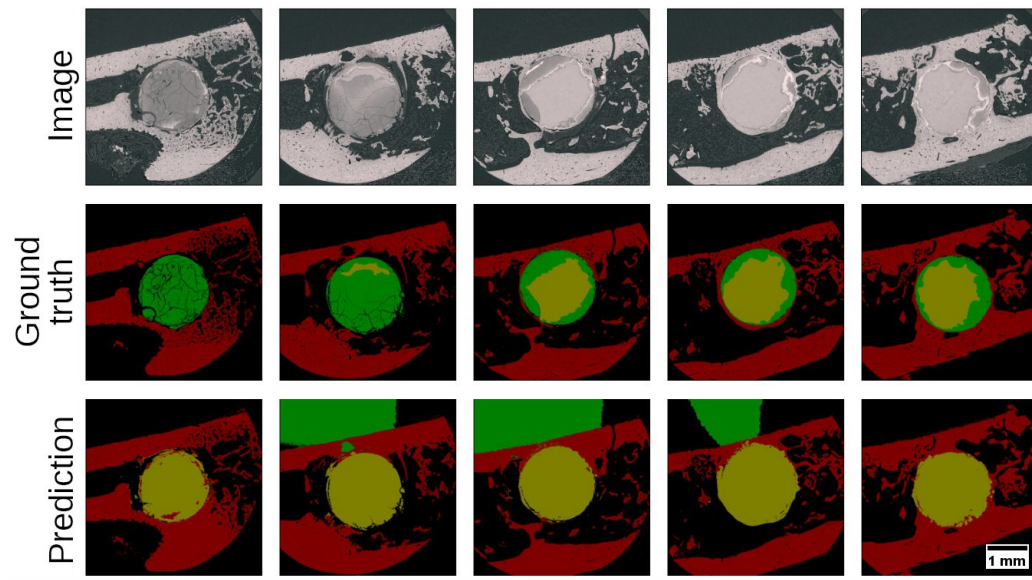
Unsupervised segmentation with retrained segmentation head. Application of STEGO models after retraining of the segmentation head with images from the SR- μ CT dataset and their application to test data.
